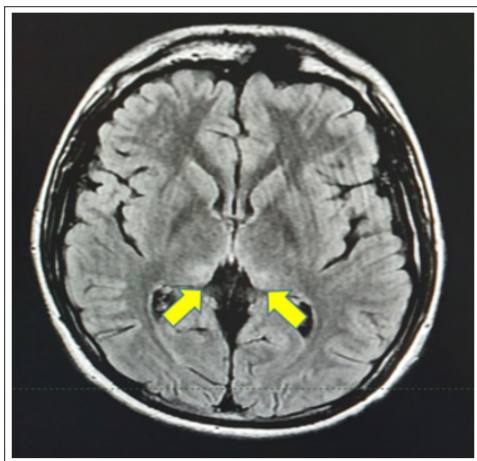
Brain magnetic resonance T2 Axial FLAIR view showing bilateral symmetrical increased signal intensity of both thalami (yellow arrows).
